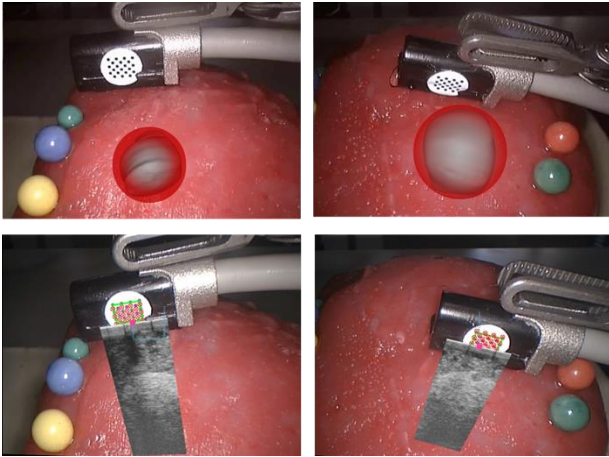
Top row: the reconstructed tumour is overlaid on laparoscopic images to provide an augmented view for tumour localisation and diagnosis. Bottom row: ultrasound image is overlaid according to current position of the probe. Left and right column show examples of the 10mm and 15mm tumour respectively.
